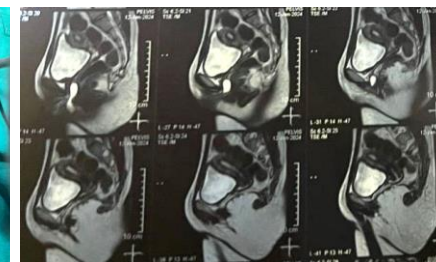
MRI showing hypointense band in the mid-lower 1/3rd vaginal junction
